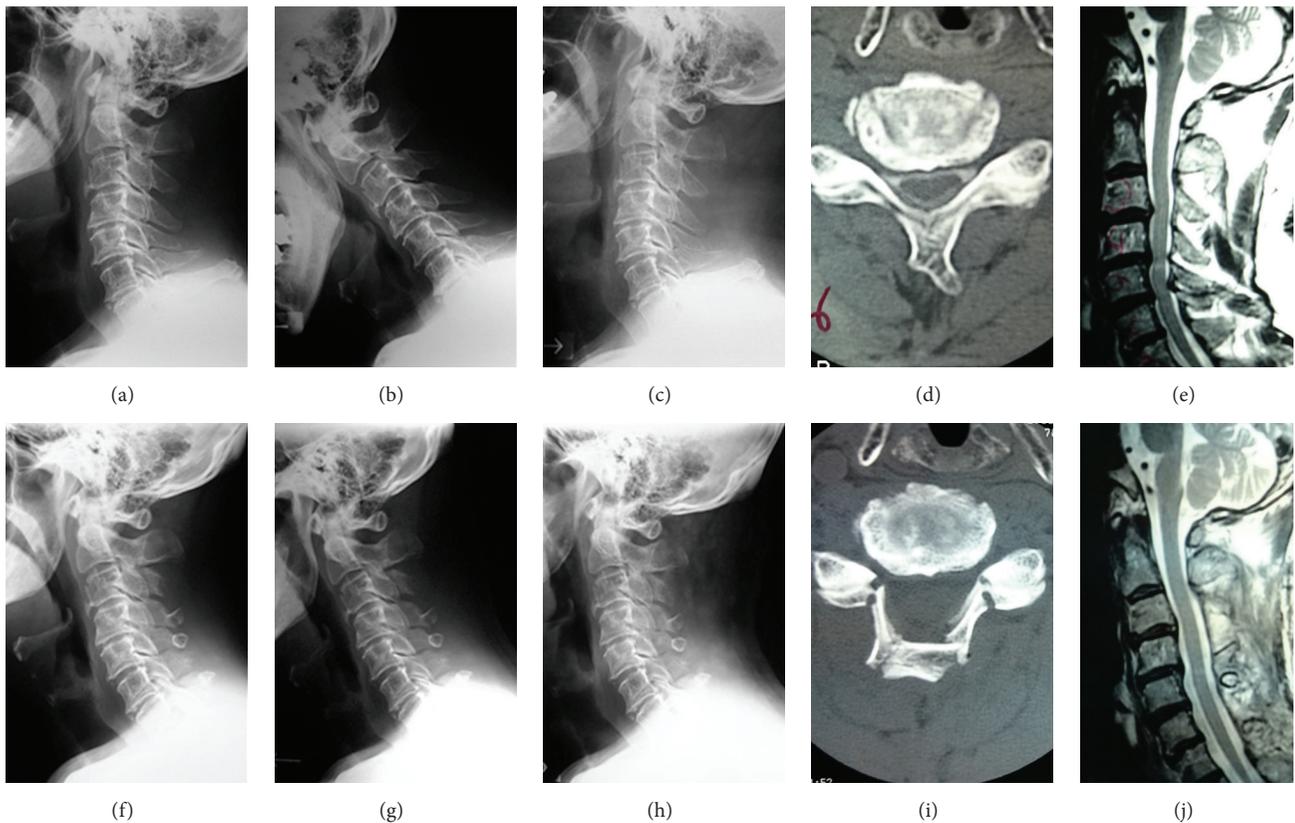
A 79-year-old man who underwent C4–7 laminoplasty for cervical spondylotic myelopathy. Pre- (a–e) and postoperative (f–j) radiographs, CT, and MRI images are shown. Pre/postoperative C2/7 Cobb angles and range of motion were 17/15 and 46/32 degrees, respectively. This patient was not able to walk before surgery but got managed to walk after surgery. However, he developed severe dementia and died 4 years after surgery. Pre- and postoperative (24 months) JOA scores were 5 and 7, respectively.
